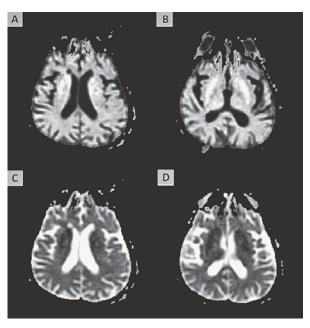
Brain MRI taken on January 7, 2013: restricted diffusion demonstrated in basal ganglia and periventricular white matter on DWI and ADC images.
